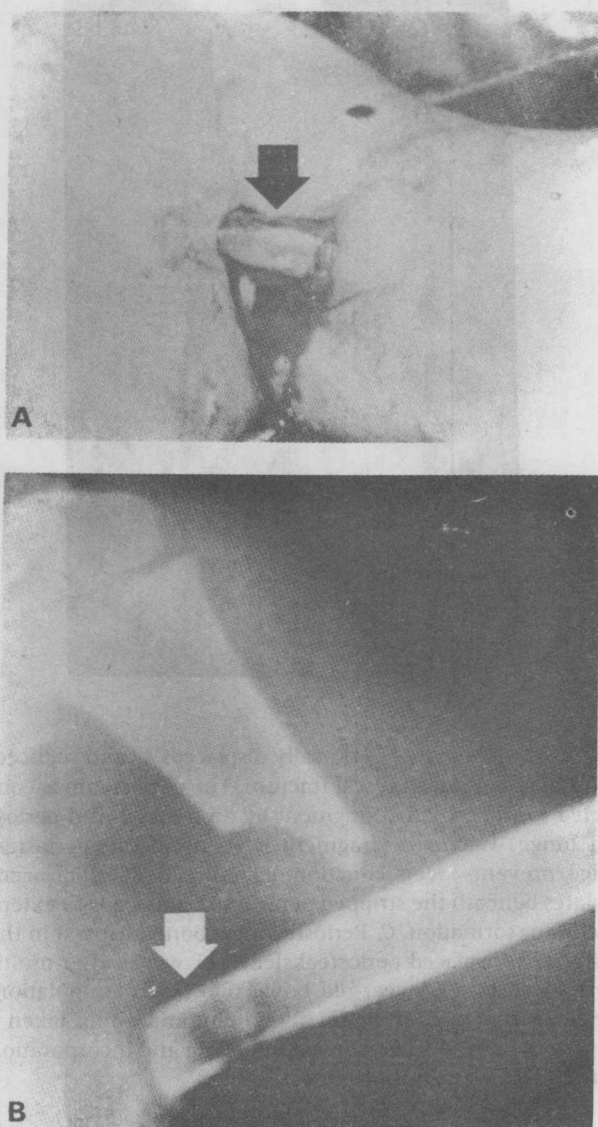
A, Compound fracture of the proximal humeral metaphysis in a seven-year-old girl. B, Roentgenogram showing air in the soft tissues. The extracorporeal segment is indicated by the arrow.
